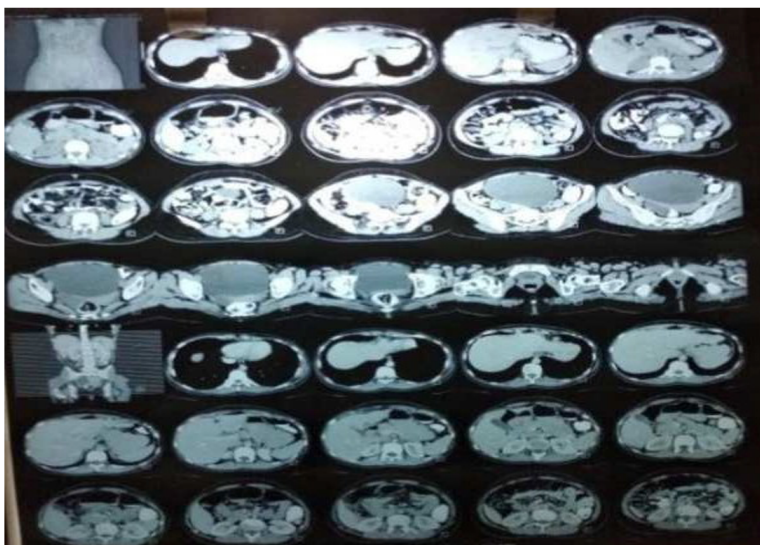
CT with B/L Ovary
